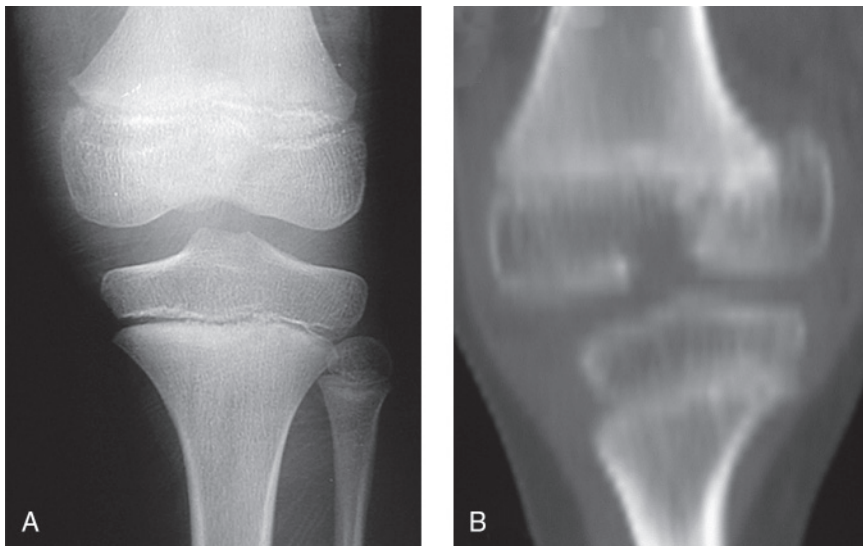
A, AP radiograph of a Salter-Harris type III fracture of the distal femur in an 11-year-old boy. B, CT scan of the fracture.
